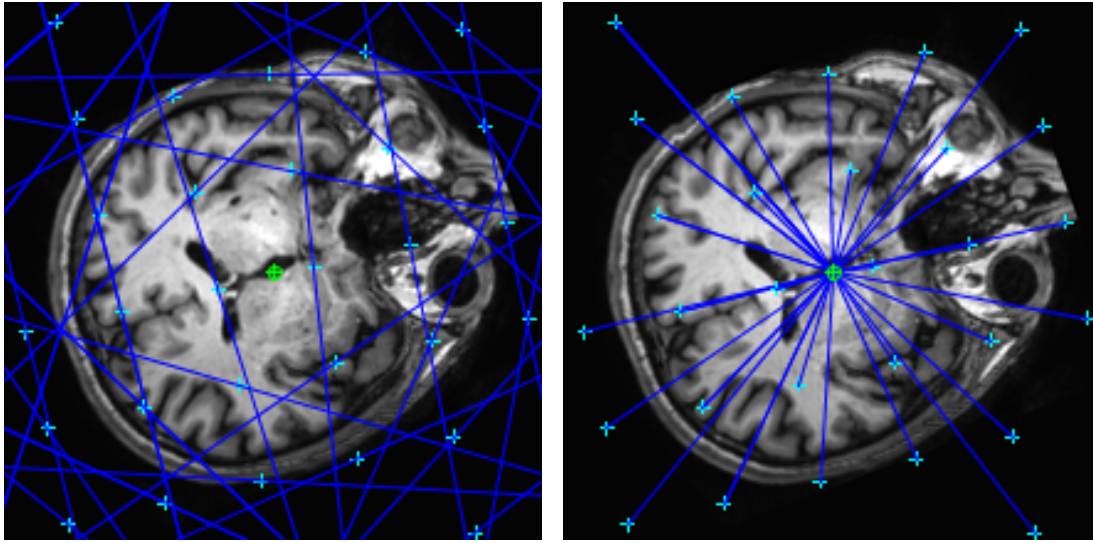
Two examples (left: test lines for the INV method, right: test ray lengths for the DN method) for the ‘grid_inv_dn.txt’ script, which are both overlaid on a slice of IR rotated brain MR image.
